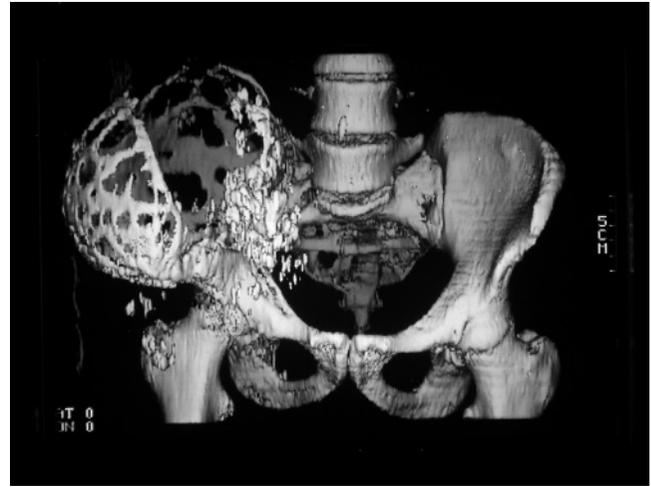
This figure clearly shows a computed tomography reconstruction of the pseudotumor, which has fragments of the ileum surrounding the mass. Note the encroachment onto the sacrum and the destroyed sacroiliac articulation.
